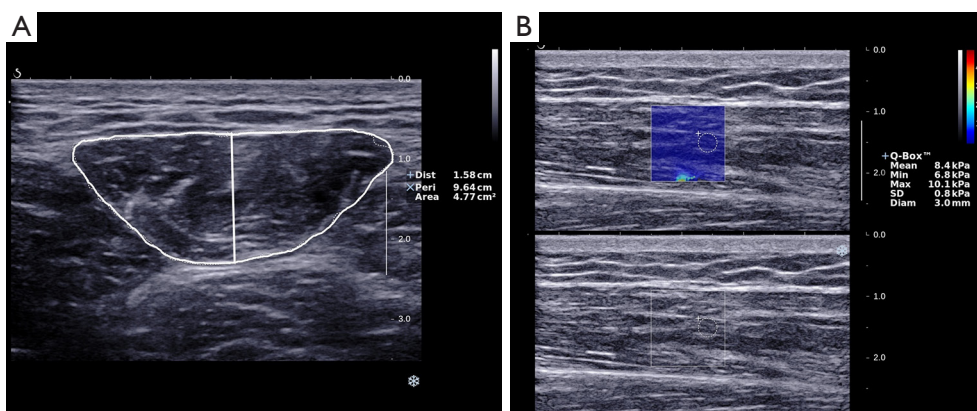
Ultrasound and SWE images of the RFM. (A) Two-dimensional ultrasound image of the RFM. The CSA and MT of the RFM were measured. (B) The SWE values of the RFM were measured (region of interest = 3 mm, depth: 1.5 cm). CSA, cross-sectional area; MT, muscle thickness; RFM, rectus femoris muscle; SWE, shear-wave elastography.
